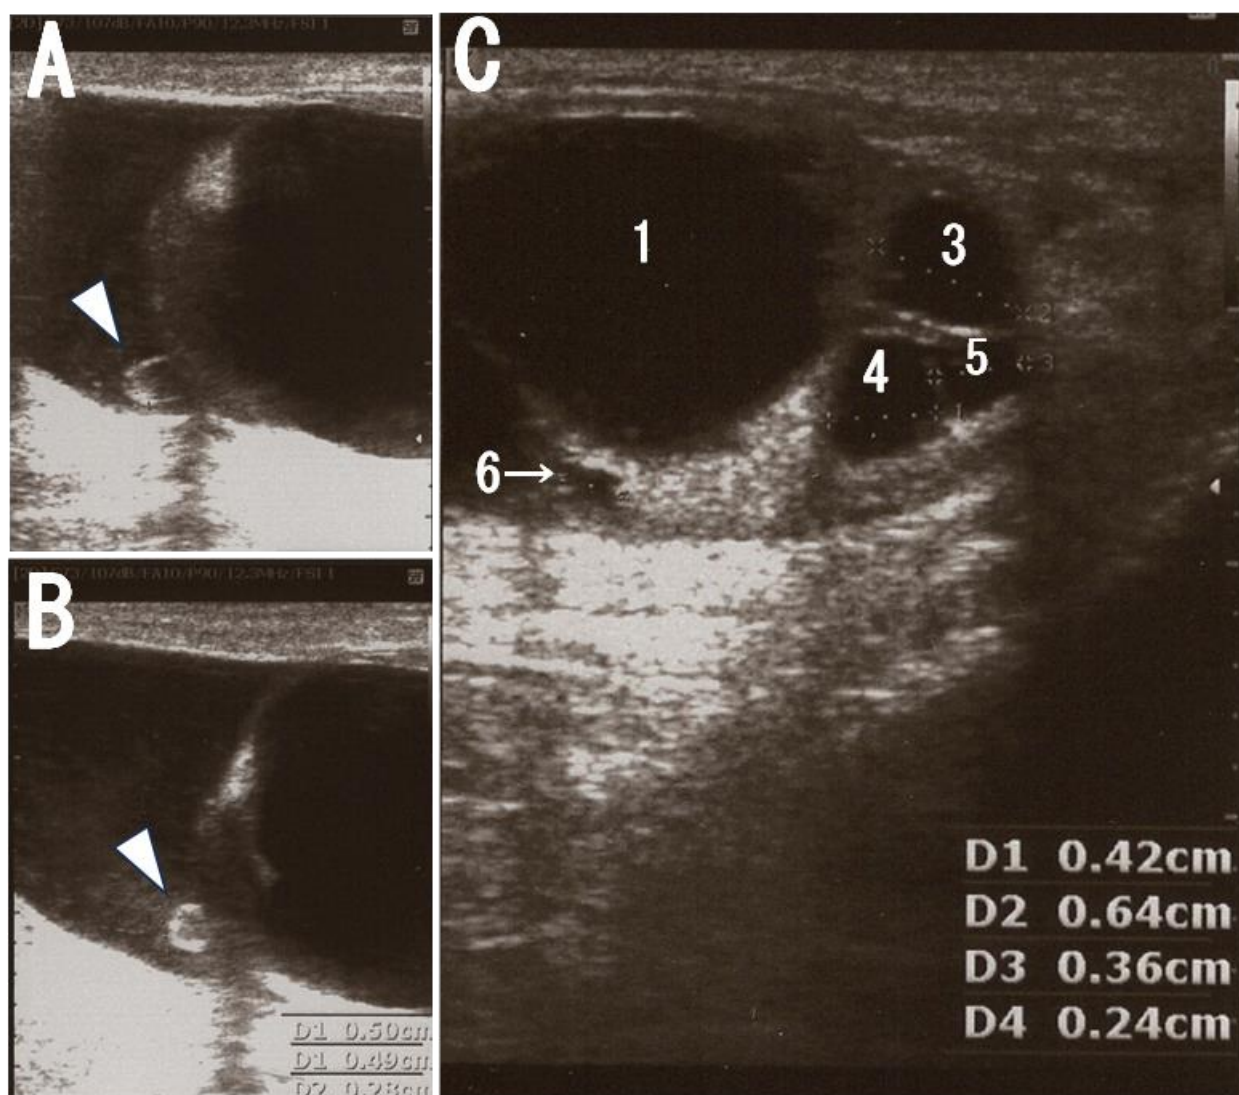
Ultrasonography of the left testis. (A) A 3.5-mm epididymal cyst in the head of the epididymis (arrowhead). (B) Another 3.5-mm epididymal cyst. (C) Multiple small cysts located caudal to the main cyst (1) measuring 6.4 mm (3), 4.2 mm (4), 2.4 mm (5), and 2 mm (6).
